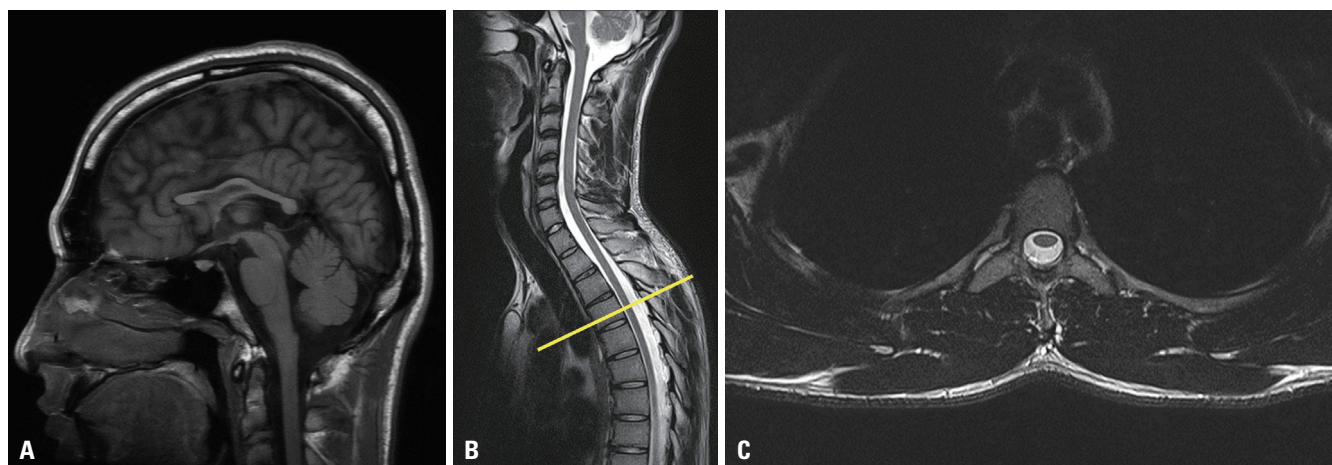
Characteristic atrophy of the corpus callosum and spinal cord in *SPG11*. Magnetic resonance images of the brain and spinal cord revealed pronounced atrophy of the corpus callosum (A) and spinal cord (B and C) in a 22-year-old male patient (F27) with pathogenic variants in *SPG11*.
